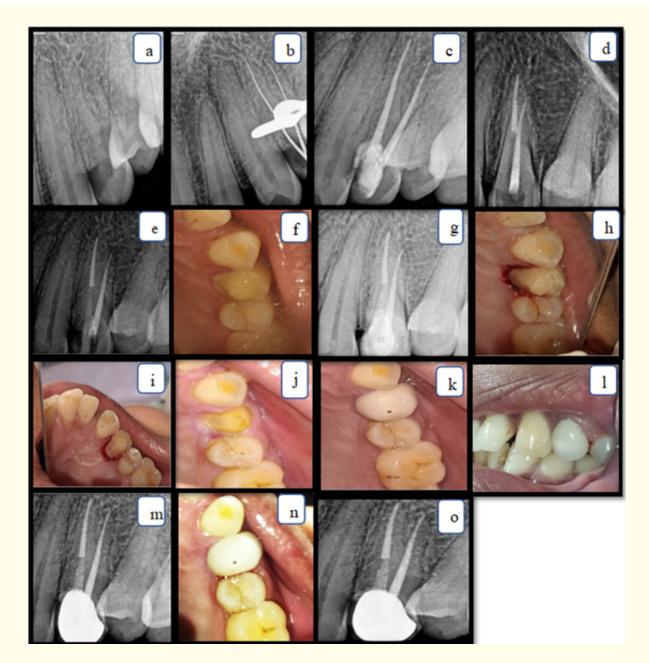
(a) pre-operative radiograph irt 24 (b) radiograph showing working length irt 24 (c) radiograph after obturation irt 24 (d) radiograph showing post space preparation irt 24 (e) radiograph showing post placement irt 24 (f) image after core build up irt 24 (g) radiograph after core build up irt 24 (h) and (i) image after crown lengthening with scalpel (j) image after crown preparation irt 24 (k) and (l) image after crown placement irt 24 (m) radiograph after crown placement irt 24 (n) image after 3 month follow up (o) radiograph after 3 month follow up.
